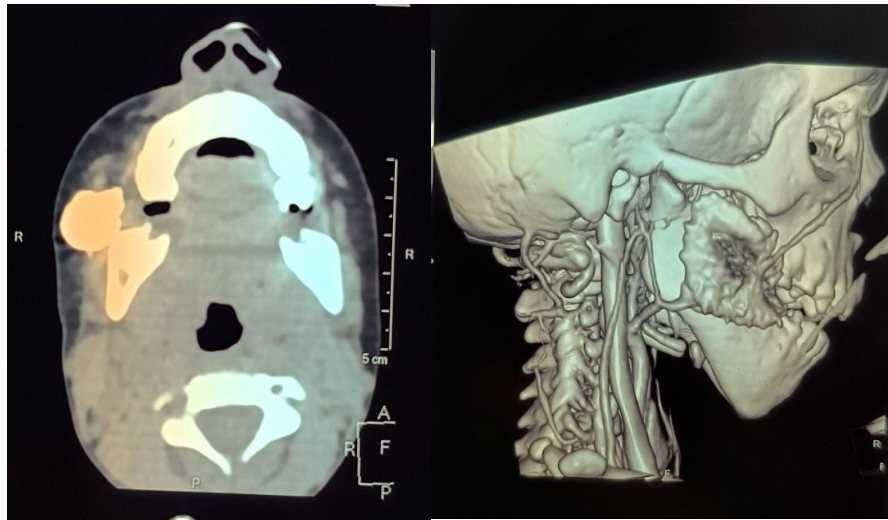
shows CT Fistulography showing a) axial section showing right accessory parotid gland with right parotid agenesis b) 3D reconstruction showing right accessory parotid gland
